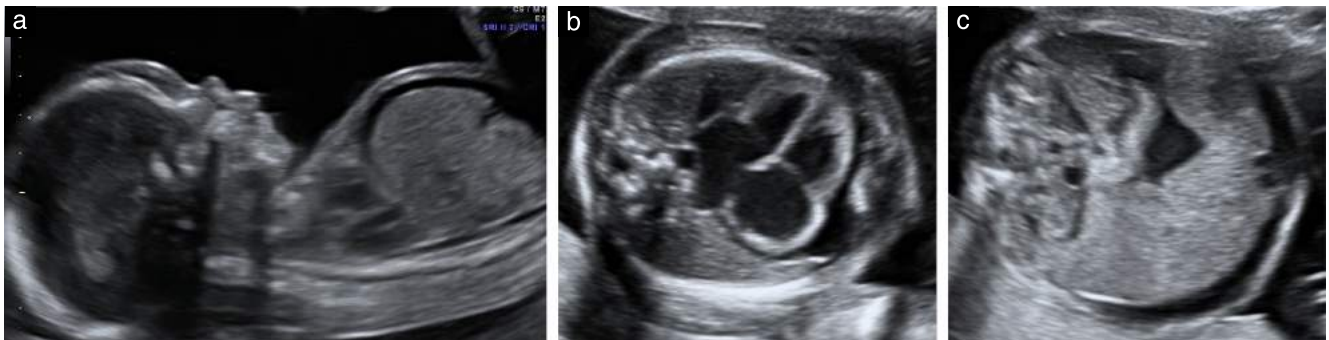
Typical hydropic ultrasound findings in fetuses with congenital parvovirus B19: skin edema and ascites (a); cardiomegaly, pericardial effusion and skin edema (b) and ascites (c).
